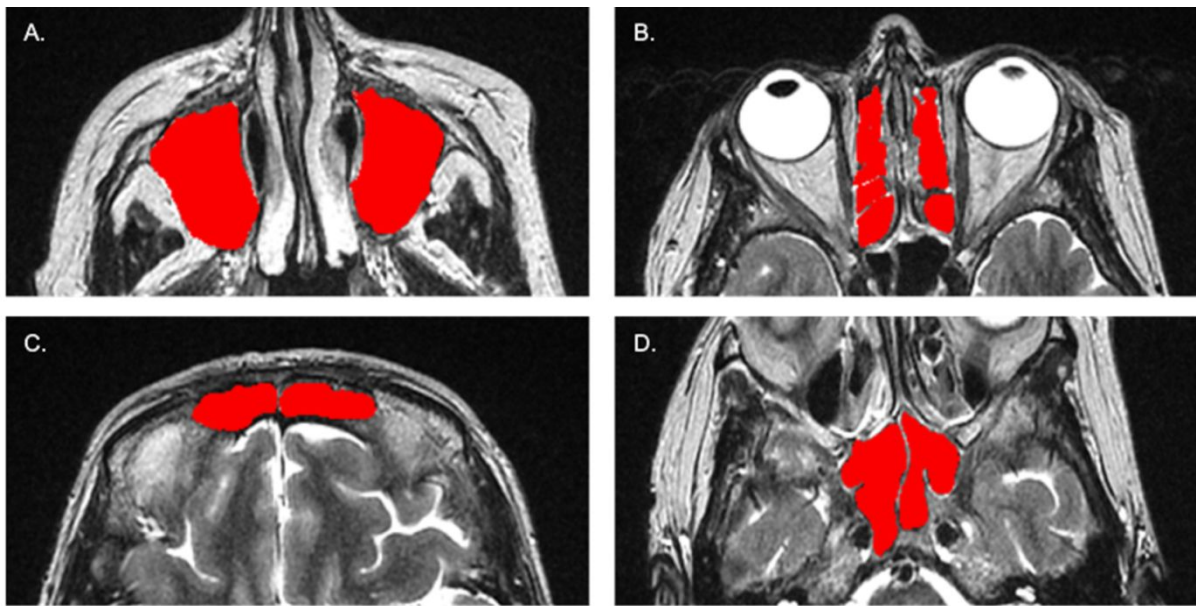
Axial MRI images of a patient showing the four different pairs of sinuses that were manually segmented using the MRICron software, and these region of interest masks were used for calculating the computational volumes. (A) Maxillary sinuses. (B) Ethmoid sinuses. (C) Frontal sinuses. (D) Sphenoid sinuses.
